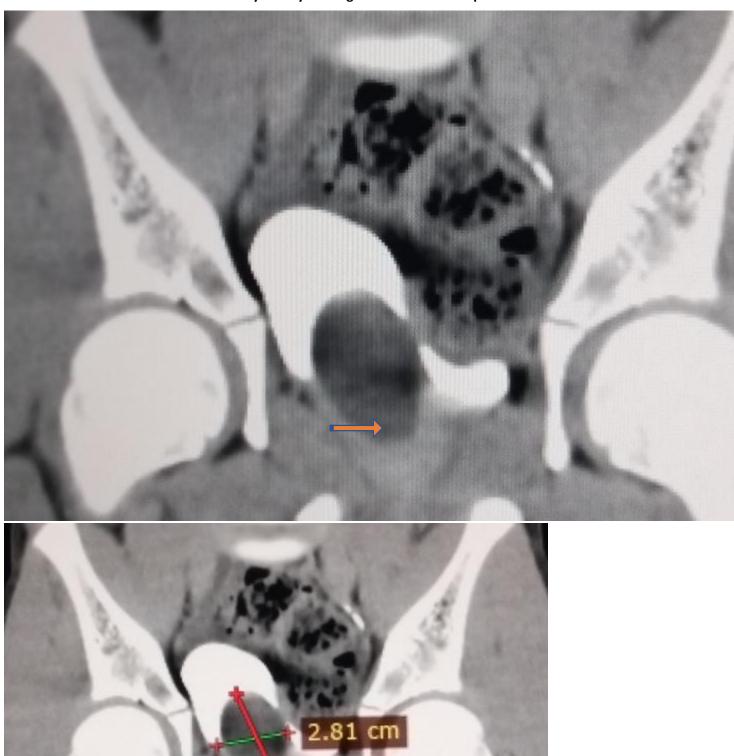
and 6b coronal reformats contrast enhanced computed tomography showing the ureterocele as a filling defect within the contrast opacified urinary bladder(slim orange arrow) with its dimensions.
